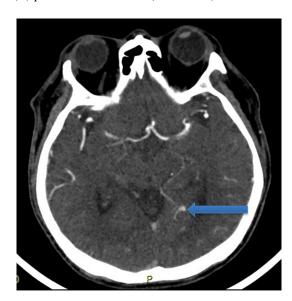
CT Angiogram demonstrates a small mycotic aneurysm arising from the distal left posterior cerebral artery in the P4 division
